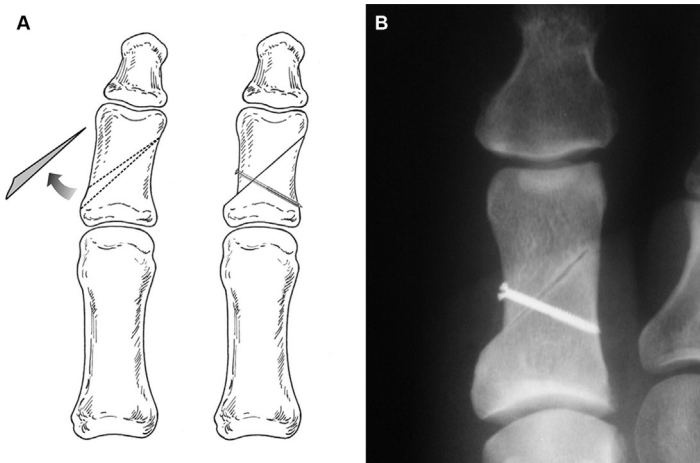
(A) Modified Akin osteotomy. The obliquity of the cut increases the osteotomy area, smoothing the correction, allowing almost perpendicular screw fixation, and possibly speeding bone healing. (B) Radiograph of the phalanx after modified Akin osteotomy. (From Sanhudo JA. Clinical tip: modified Akin osteotomy. *Foot Ankle Int.* 2005; 26(10): 901-902; with permission.)
